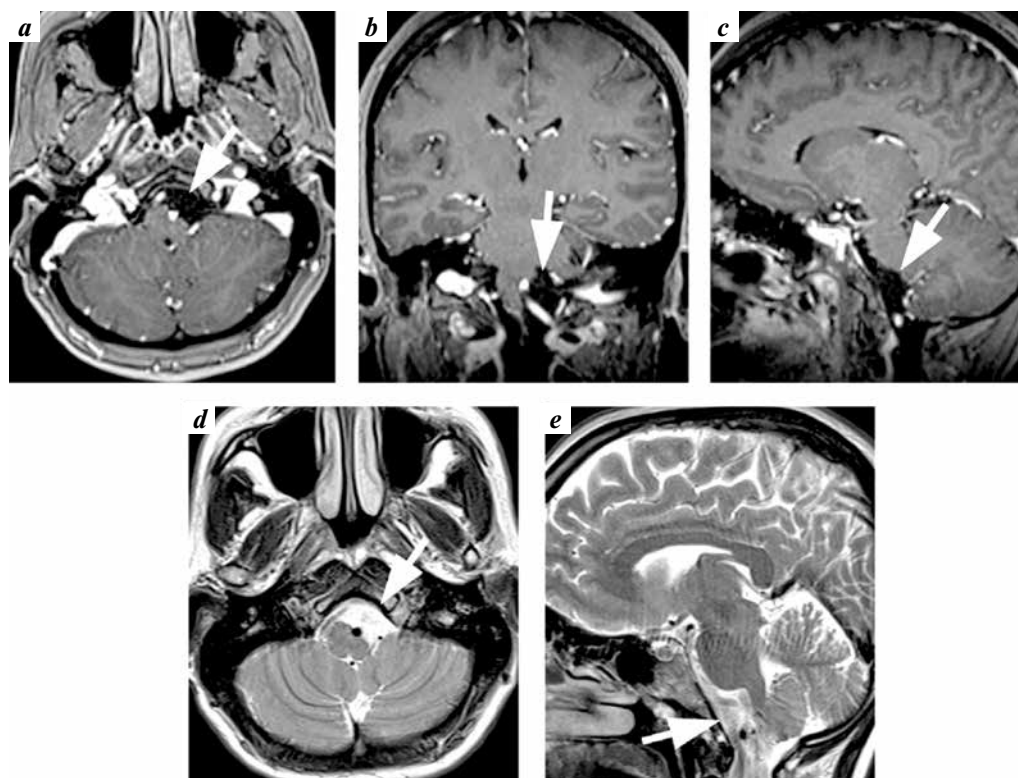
MRI scan demonstrated the presence of an unenhancing hypointense in T1W lesion in the CPA (*a–c*) and iso- to hyperintense in T2W (*d, e*)
